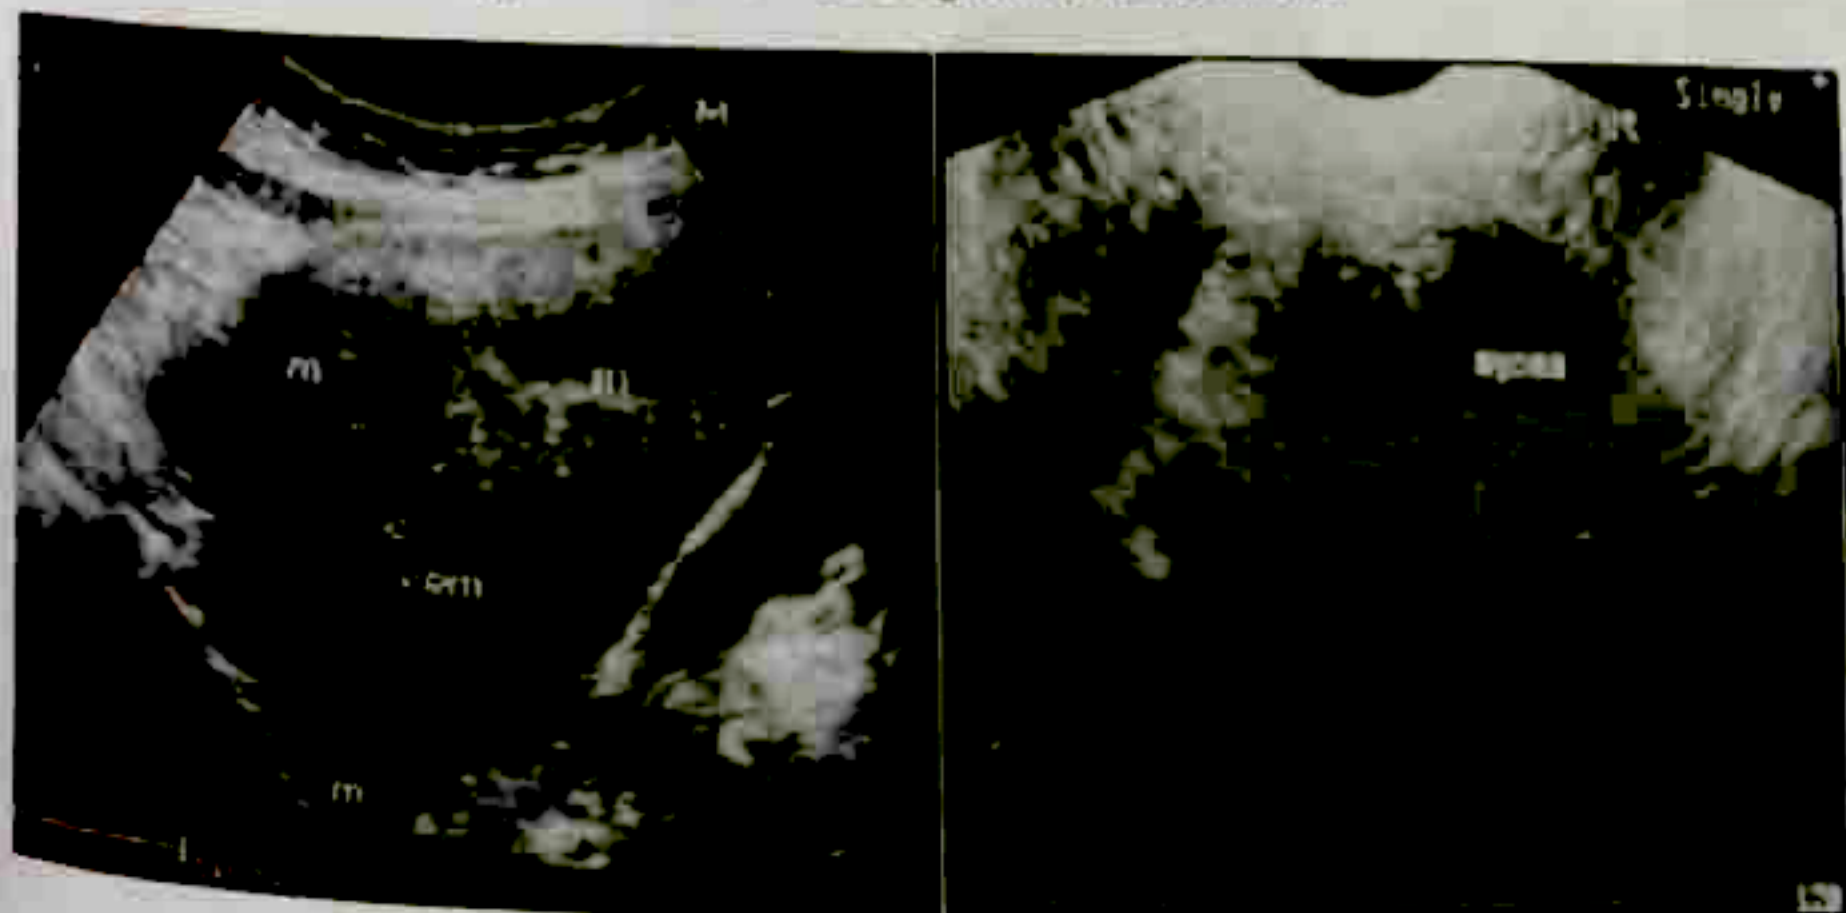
Transvaginal sonography of the pelvis. Left - scan done on initial consult showing the uterus with multiple myoma uteri and thin endometrium. Right - scan done on admission showing the huge leiomyoma between the two uterine corpuses.
